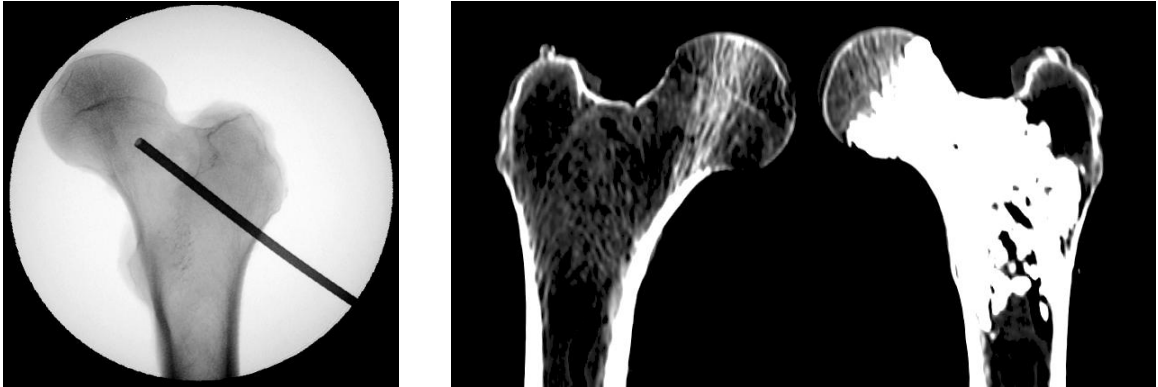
Radiograph of cannula path for a conventional augmentation (left) and CT slice of a pair of osteoporotic femora (right), one intact and one augmented with the conventional gross filling method.
